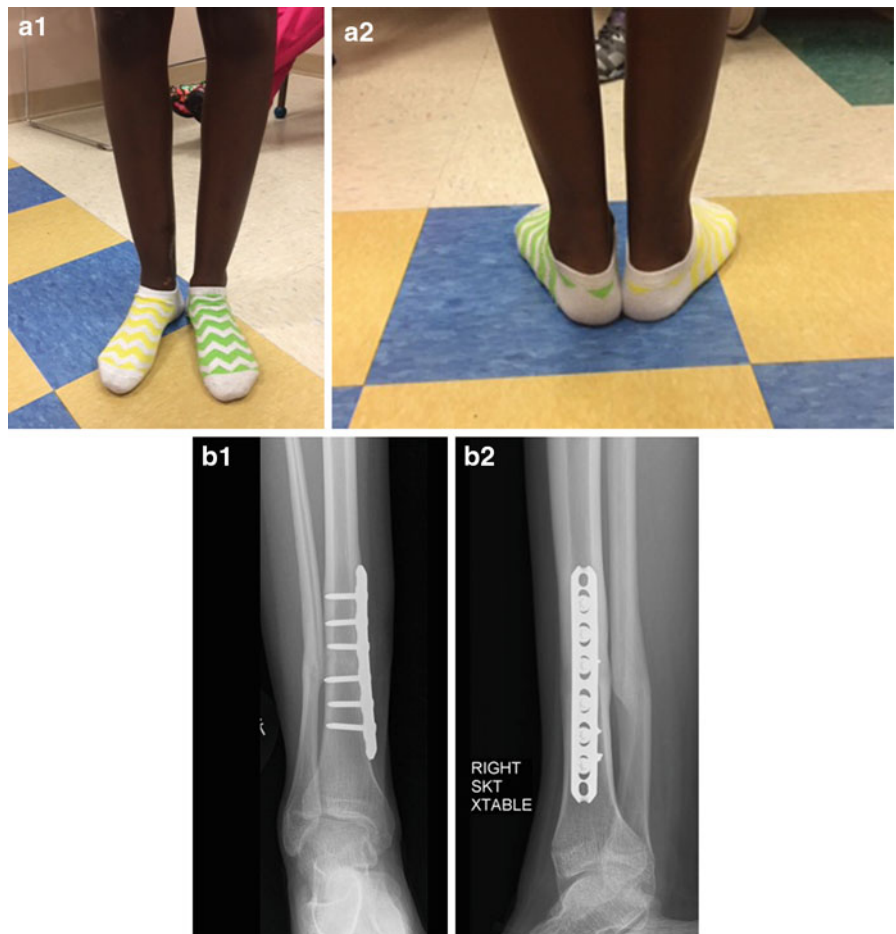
Clinical photos (a) and radiographic images (b) 1 year after surgery showing symmetric lower extremity alignment and remodeling of the tibia. The patient participates in dance without pain or functional difficulties
